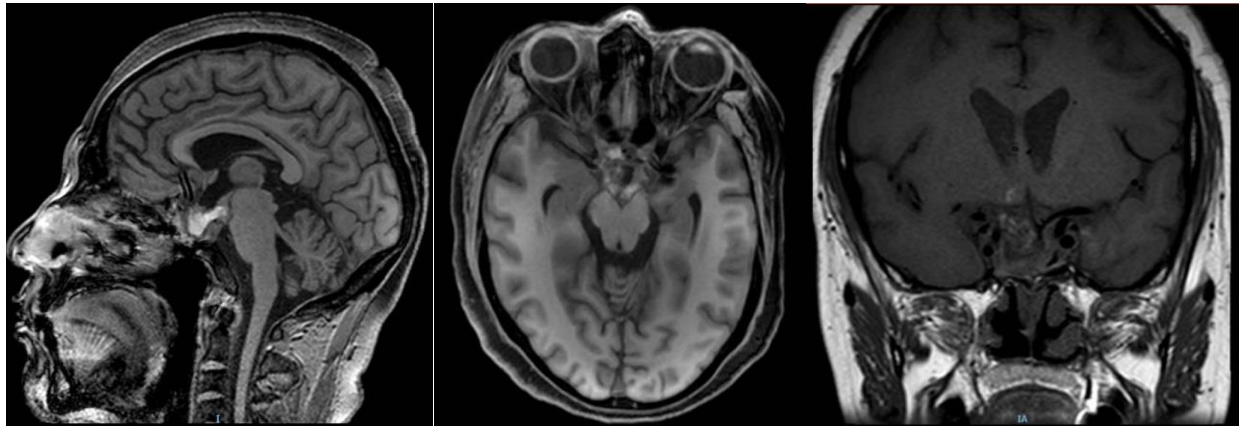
MRI images of the control sellar region after surgery and 3 weeks of antibiotic therapy. Note the resolution of the lesion, but discreet enhancement in the abscess capsule persists.
